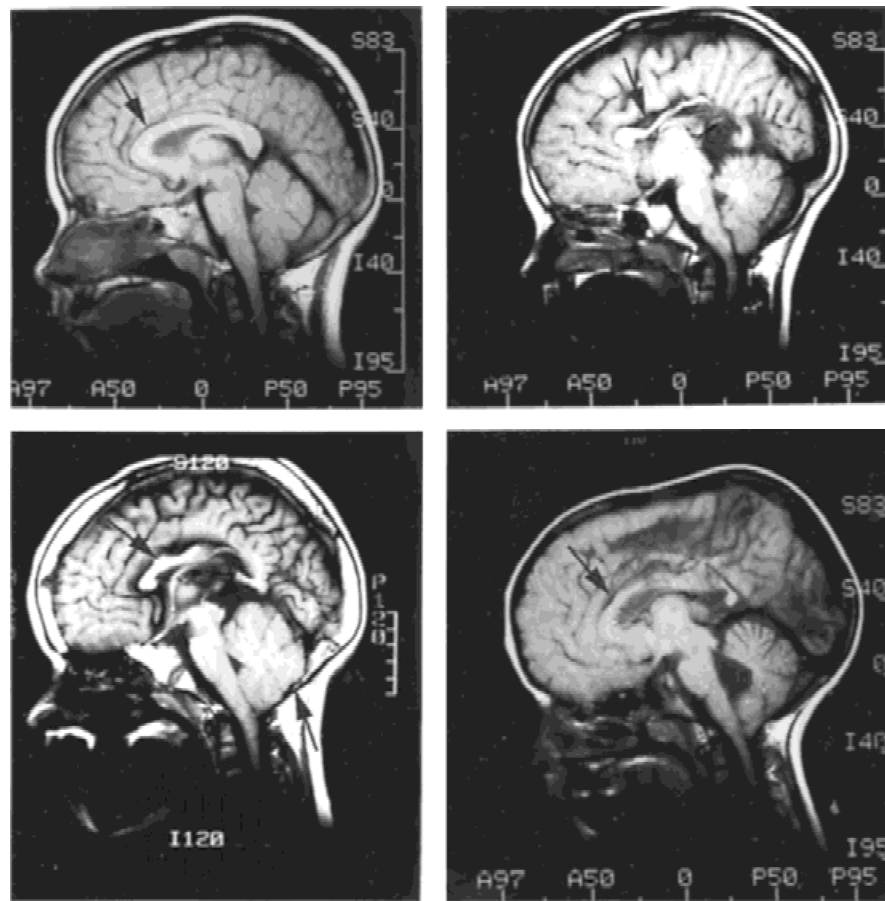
Midsagittal slice from MRI of 4 children with spina bifida meningocele. Variability in the structure of the corpus callosum (arrows) is demonstrated and include a normal corpus callosum (upper left panel), a hypoplastic corpus callosum (upper right panel), and partial agenesis of the corpus callosum (lower left and right panels). (Reprinted with permission from Hannay et al., in press.)
